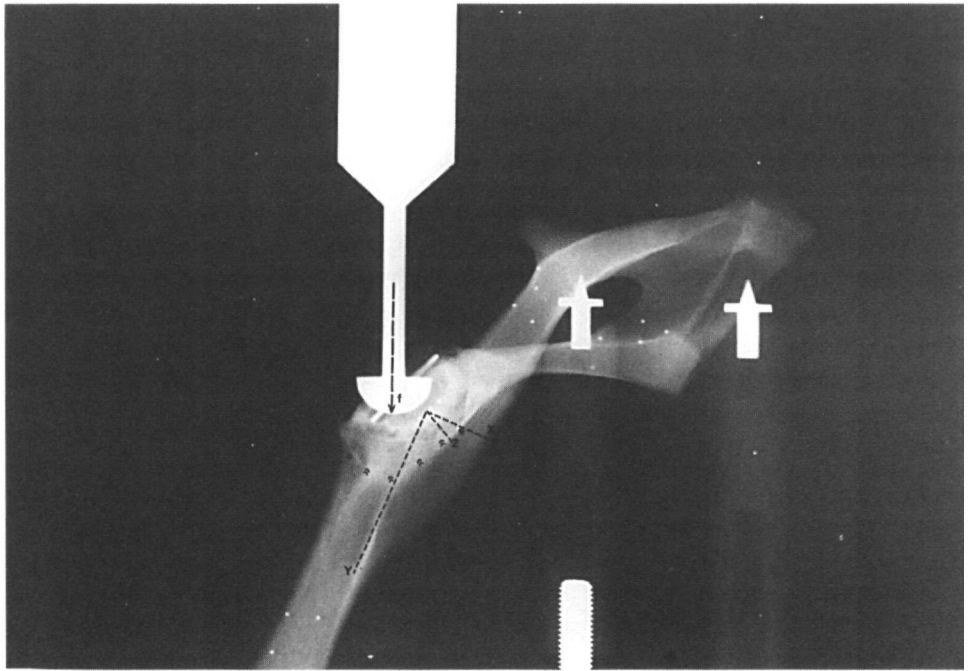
Radiograph of same left pelvis as in fig. 4.5b mounted in MTS machine during load application. Laboratory coordinate system is shown. Arrowheads are pointing to the graft.
